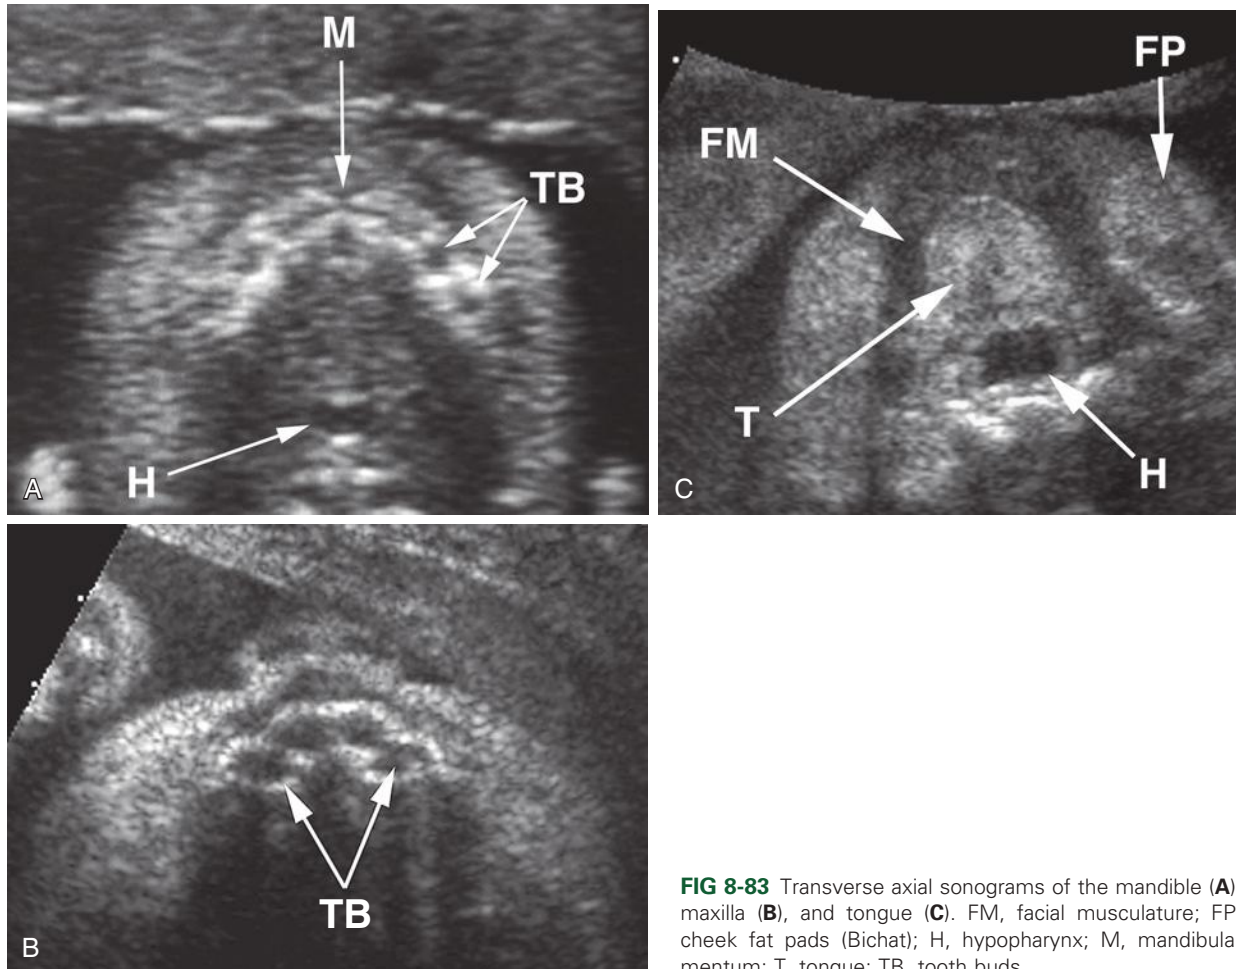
Transverse axial sonograms of the mandible (A), maxilla (B), and tongue (C). FM, facial musculature; FP, cheek fat pads (Bichat); H, hypopharynx; M, mandibular mentum; T, tongue; TB, tooth buds.
